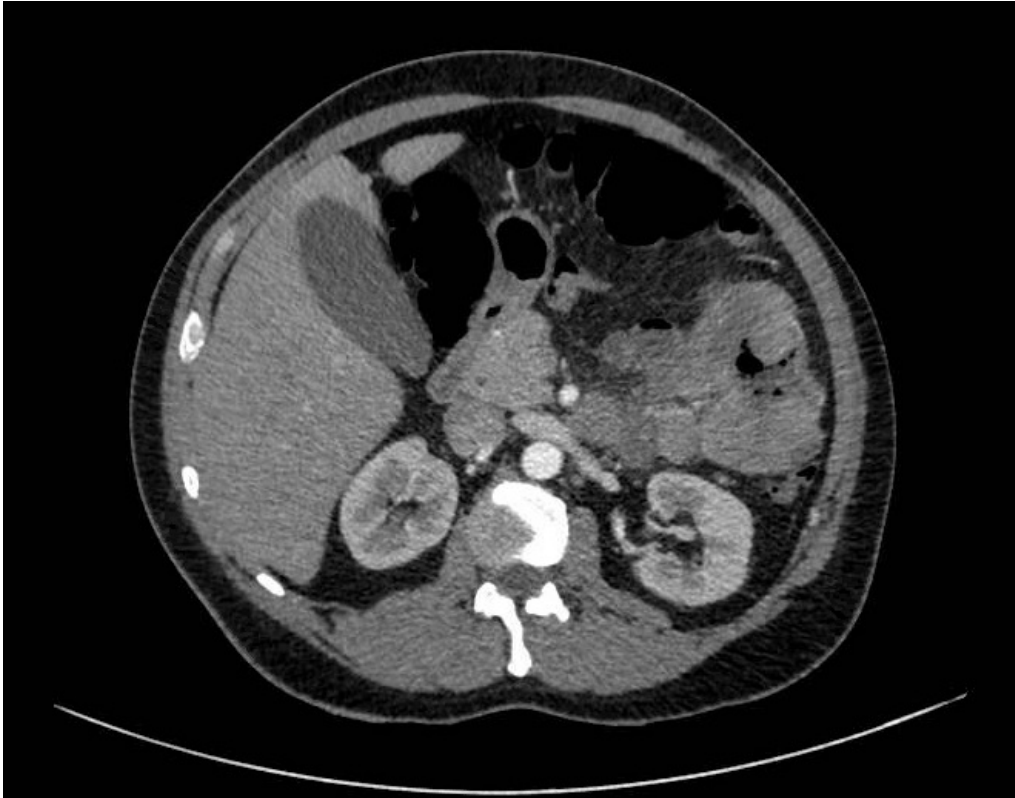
Transverse section of abdominal computed tomography which shows an aneurismatic dilation of the jejunum with adjacent adenopathies.
